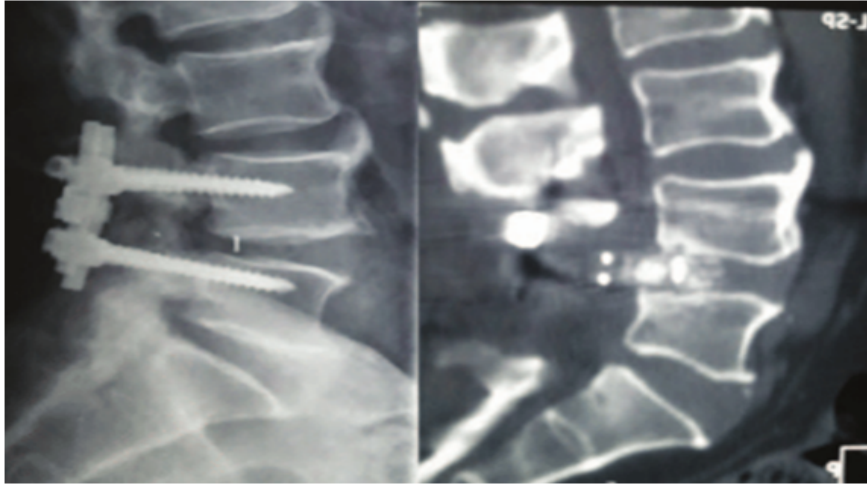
Pre-Op and Post Op X-ray of patients treated by TLIF
